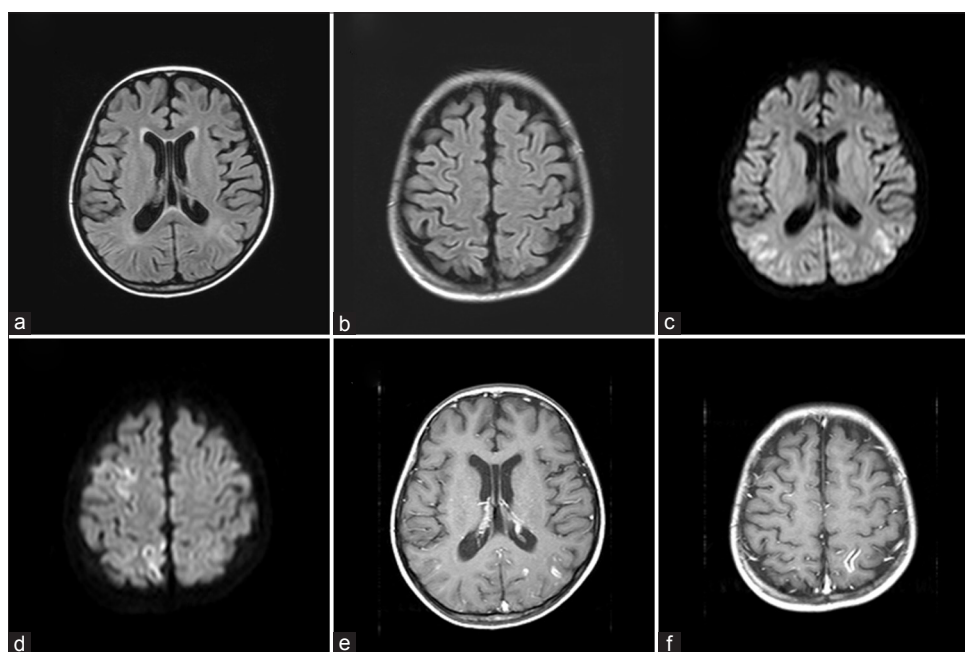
Initial brain magnetic resonance images. Slightly hyperintense areas were found in bilateral parietal, occipital lobes and right frontal lobe, predominantly in the subcortical white matter and cortex, on fluid-attenuated inversion recovery images (a and b). Hyperintense areas also appeared high signal on diffusion weighted imaging (c and d). Linear and punctate intense enhancements in cortical and subcortical areas were found on gadolinium-enhanced T1-weighted images (e and f).
